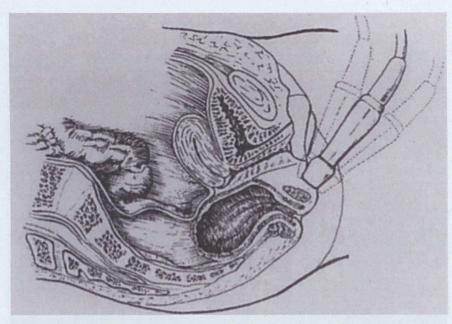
Transperineal ultrasound.
